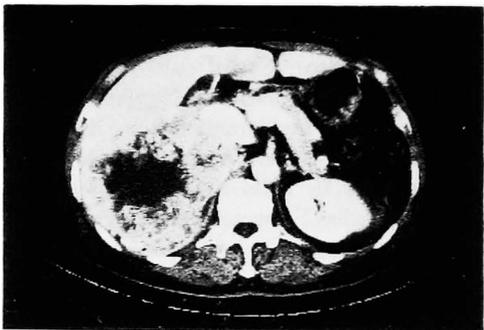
A CT scan of a right renal cell carcinoma. Tumor invasion into the liver is not discernible.
